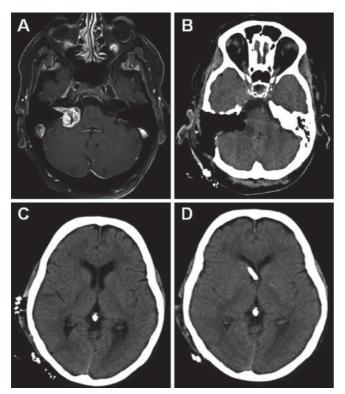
(A) Preoperative MRI showing a right sided CPA tumor with intracanalicular extension. (B) Postoperative CT showing complete tumor removal through a translabyrinthine approach. (C) CT on the fourth postoperative day revealing mild ventricular dilation and cortical edema. D) CT after EVD placement with resolution of hydrocephalus.
